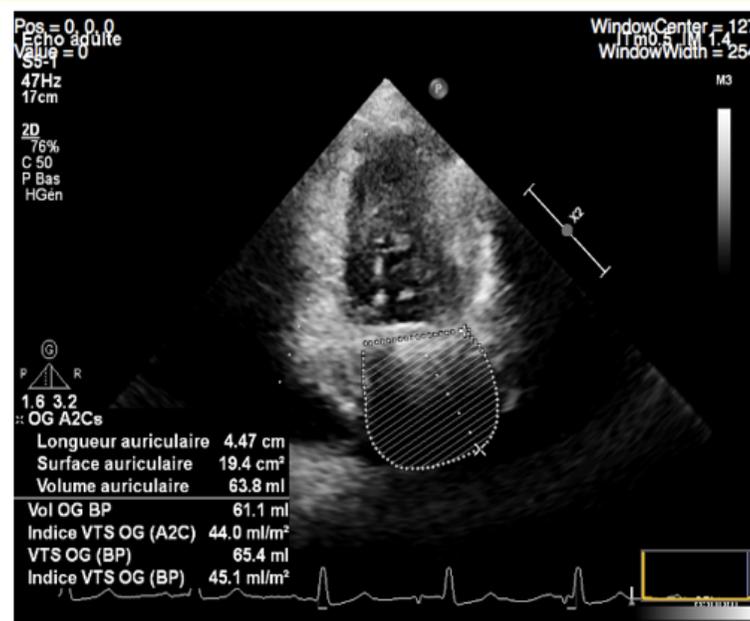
Left atrial volume on apical two chamber.
